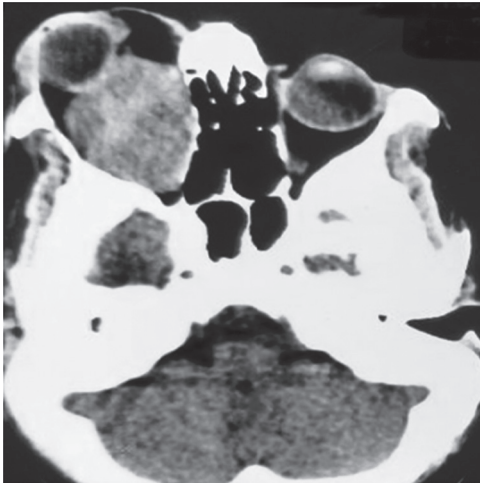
Computed tomography imaging of the brain showing intraocular space occupying lesion in the right eye isodense to brain parenchyma without hemorrhage or calcification
